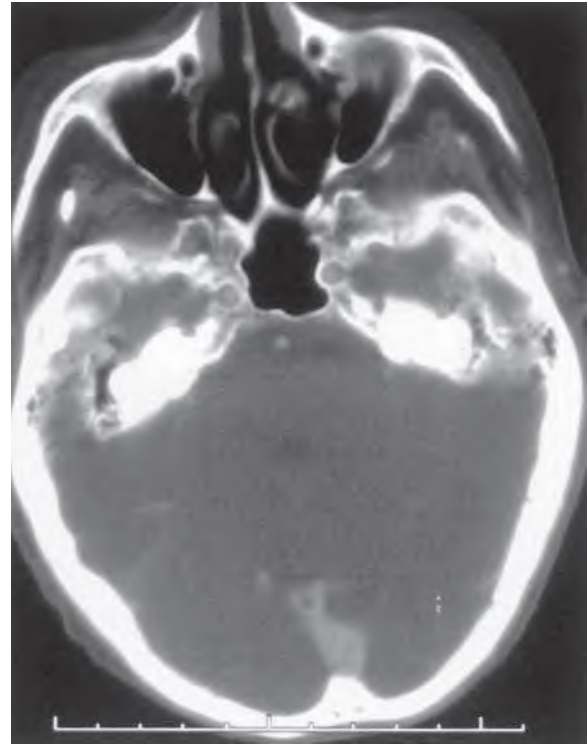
Computed tomography of sinuses showing sinus wall thickening.
